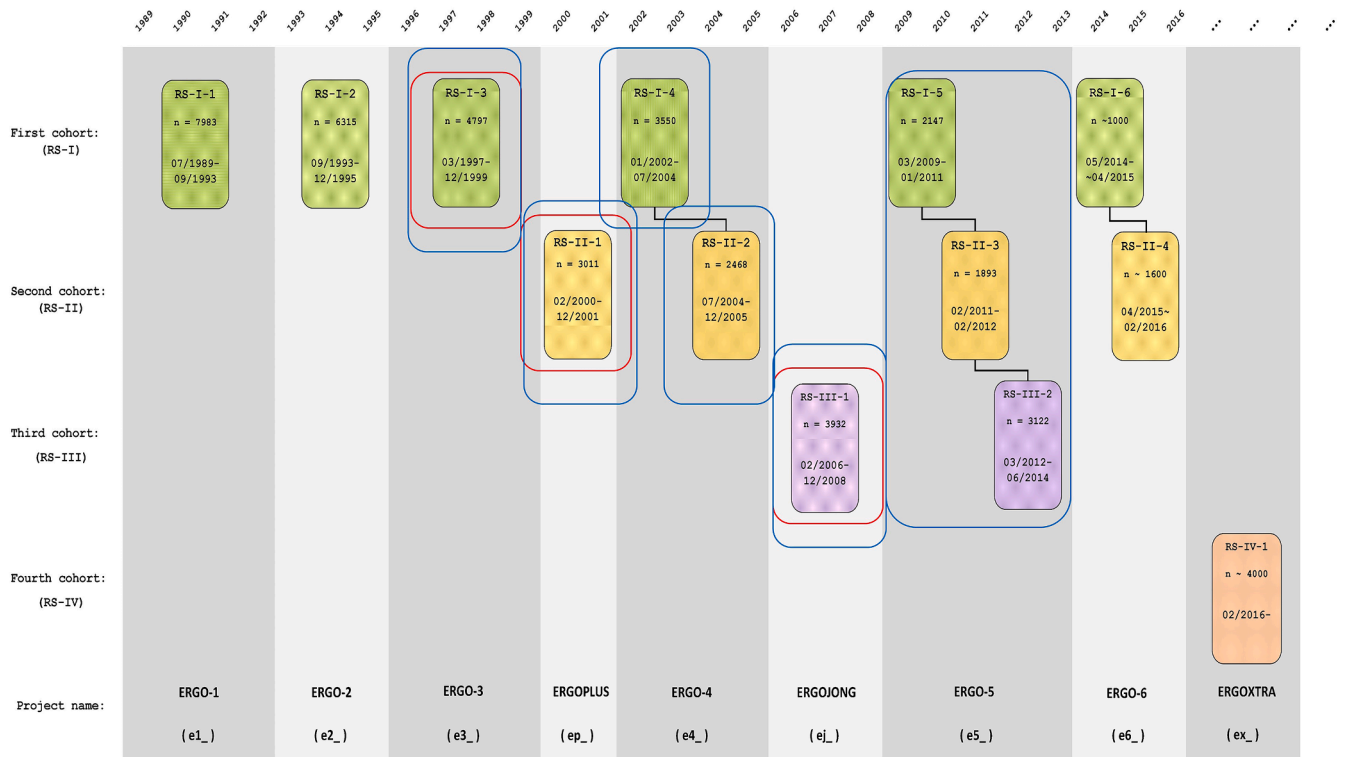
Overview of the Rotterdam Study cohorts. For the present study we used data on osteoarthritis assessed by X-ray at visits RS-I- 3, 4, 5, RS-II- 1, 2, 3 and RS-III- 1, 2 (in blue frame) and the exposures/metabolic factors assessed at visits RS-I-3, RS-II-1 and RS-III-1 (in red frame). Figure was adapted from article published by Hofman et al., 2015 under license CC BY 4.0 (<http://creativecommons.org/licenses/by/4.0>).
